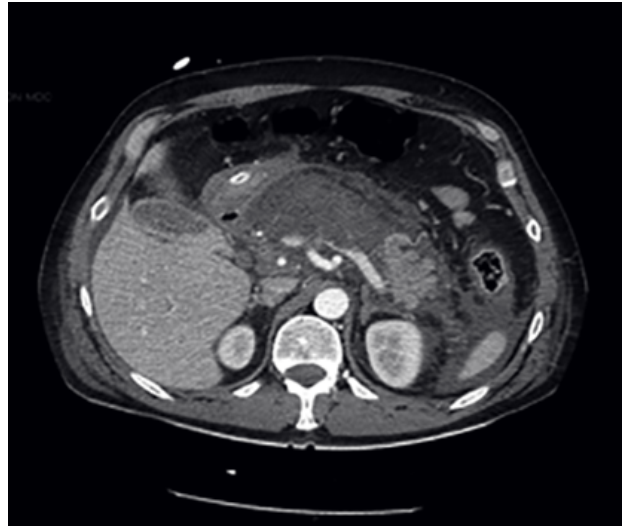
77-years-old woman: severe acute pancreatitis CT-scan image. Pancreatic structure is almost totally changed by necrotic process. Focus on the fluid, which is spread between the bowel loops.
